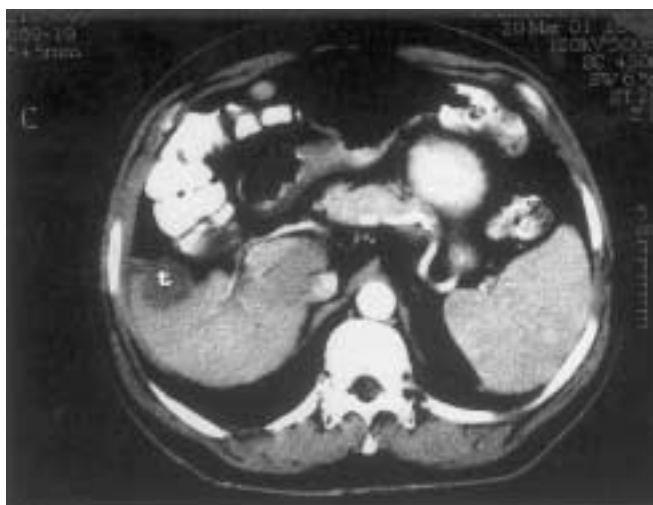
Demonstrates the tumor (t) in the right lobe of the liver. PEI: 95% ethanol is Post-PEI follow-up CT demonstrates a completely hypo-attenuated tumor (t) indicating complete ablation.
